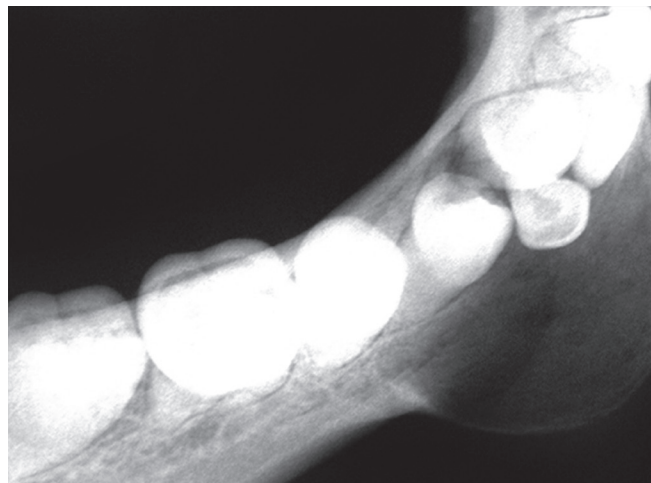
Preoperative orthopantomograph
